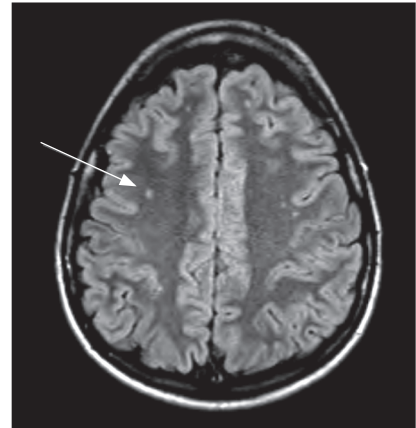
Axial, T2-weighted magnetic resonance image of the patient's brain. The arrow indicates nonspecific hyperintensities in the pericortical frontal lobe.
